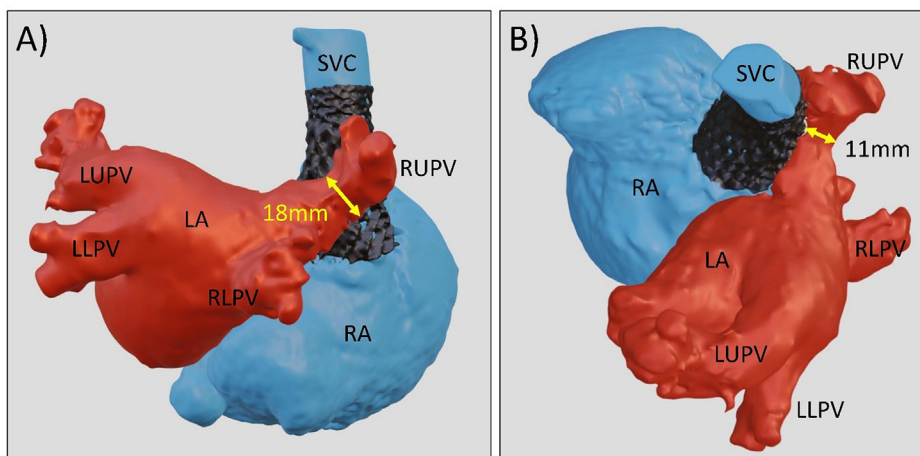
3D reconstruction after percutaneous repair of superior sinus venosus atrial septal defect: Posterior (A) and modified superior (B) view of a 3D reconstruction based on computed tomography, in a patient after percutaneous repair of superior sinus venosus atrial septal defect, using a covered, 6cm, 10zig CP stent (CP10) and a further, LD Max bare stent, implanted in the superior vena cava (SVC), in order to stabilize the CP10. Pulmonary veins, including the right upper (RUPV), right lower (RLPV), left upper (LUPV) and left lower (LLPV) are draining to the left atrium (LA), with a minimal diameter of the RUPV-LA tunnel behind the stent (arrows) at 11 × 18mm. The CP10 extends low enough to the right atrium (RA), to fully cover the atrial septal defect.
